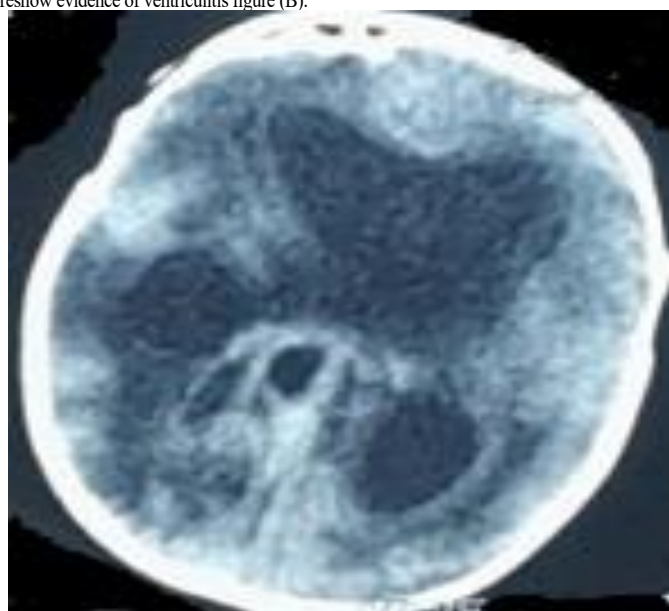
Non-contrast axial images of brain computed tomography postoperative follow-up was 2 months.
